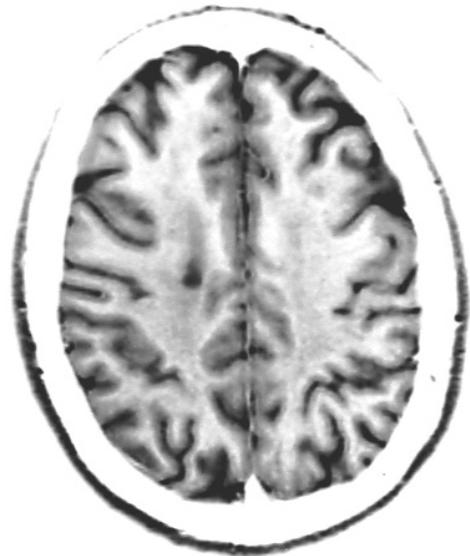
In this inverted MRI scan cerebral cortex and central white matter are shown
